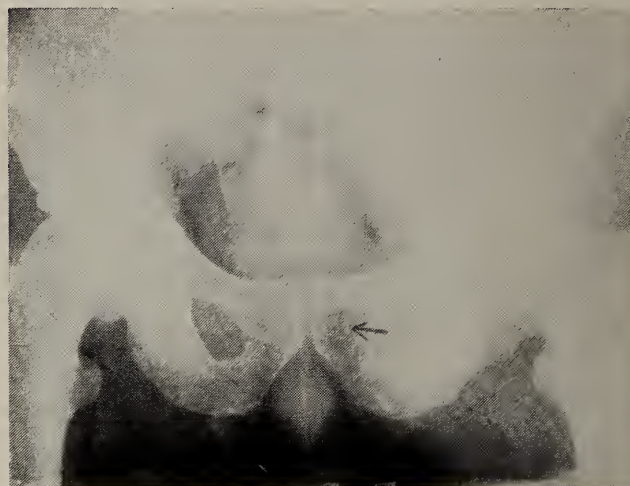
Case I. X-ray examination of pelvis showing probable metastatic carcinoma.
